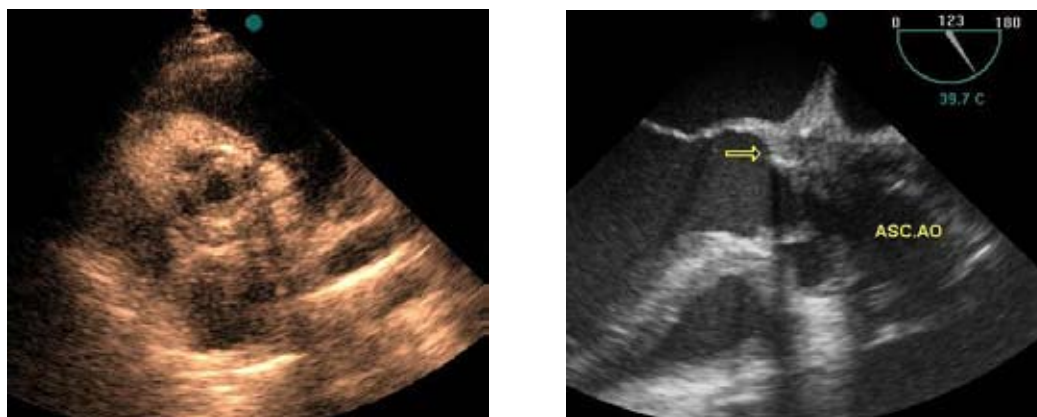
Left, transthoracic parasternal short-axis view exhibiting much thickened aortic bioprosthesis leaflets with significant obstruction secondary to commissural fusion. Right, transesophageal long-axis view of aortic valve and ascending aorta revealing severe obliteration and obstruction of ascending aorta by multiple bulky vegetations (arrow).
